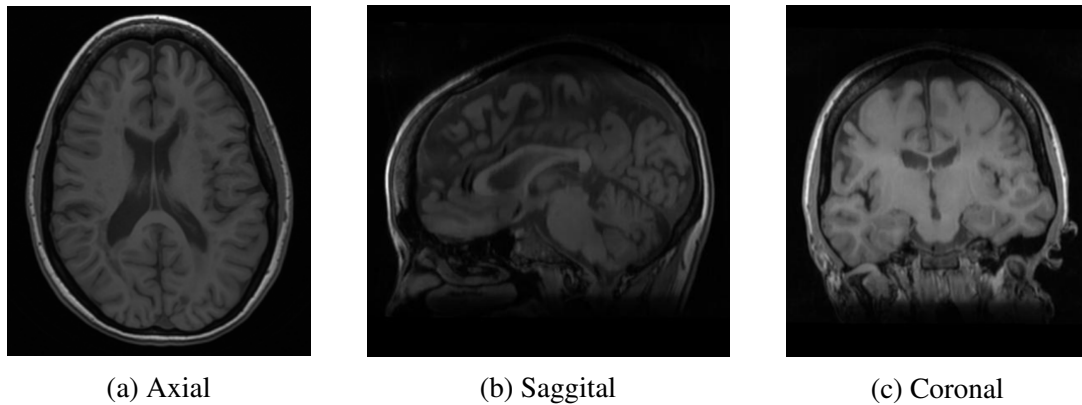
Brain MR images viewed in three planes. Three brain slices are from images of MICCAI 2008 MS lesion segmentation challenge [253].
